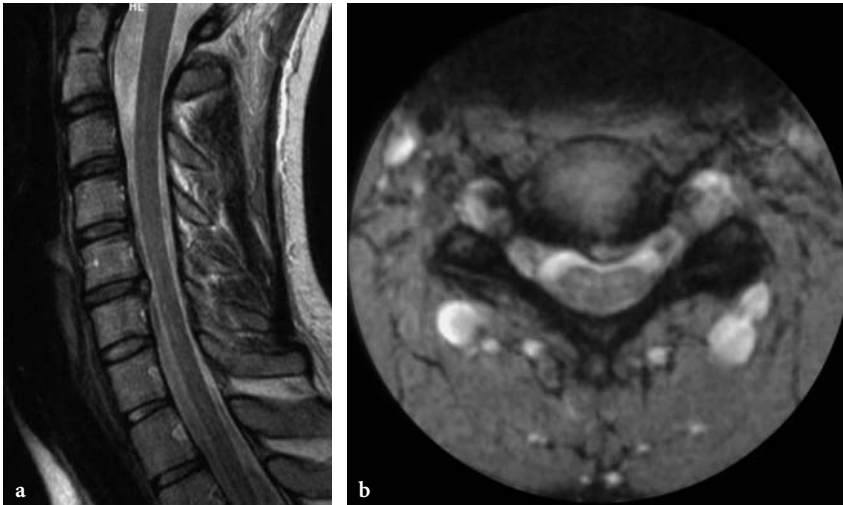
Left central disc protrusion at C5–C6 in a 26-year-old woman. Sagittal (a) and axial (b) T2-weighted images. The protruding disc is broad-based and impinges on the dural sac. It is slightly eccentric to the *left*. There is no radicular compression
